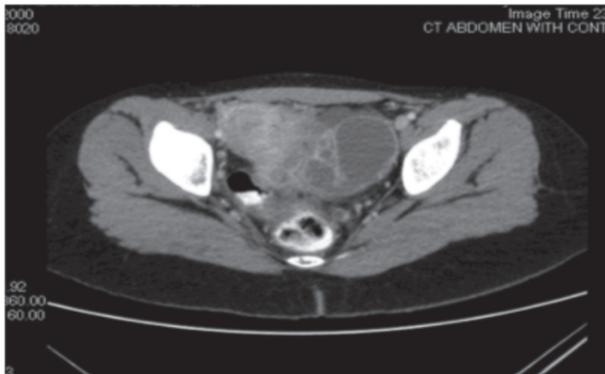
Abdominal Pelvic CT-Scan Revealed the Lesion Was Attached to the Left Side of the Uterus
